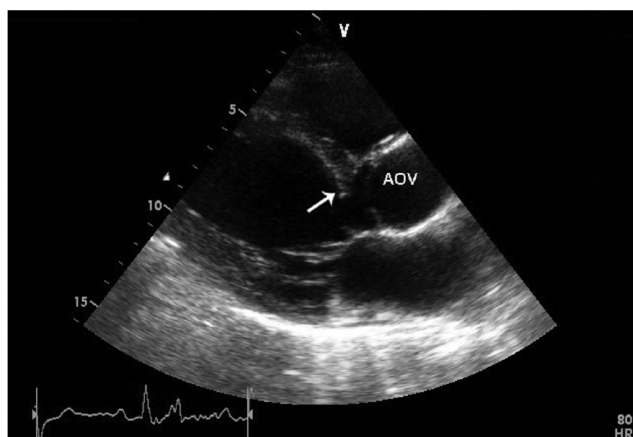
Transthoracic echocardiogram of discrete subaortic stenosis. There is a membrane below aortic valve which is attached to septum. There is another attachment to anterior mitral leaflet (arrow)
